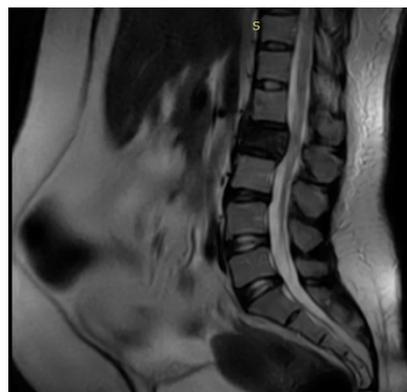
T2W sagittal MRI of the Lumbosacral spine showing collapsed L2 vertebra
